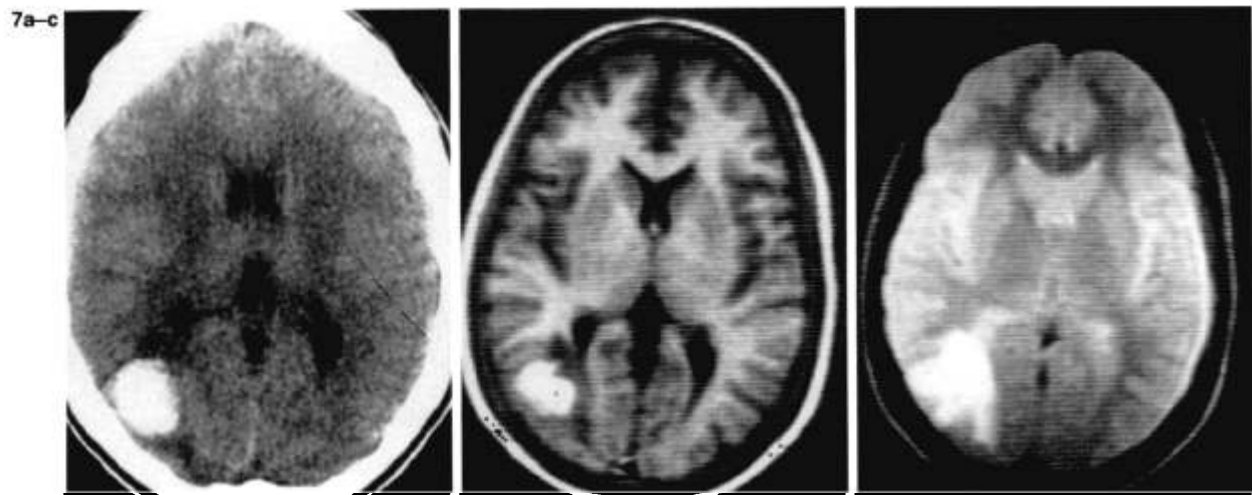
One week hematoma at 0.25 T. a: Twenty-four hours after sudden onset of seizures, noncontrast CT shows right posterior bleeding. b: T1-weighted image (IR: TR 1,700/TI 400 ms) 5 days later shows hyperintense right blood collection (T1 lowering by methemoglobin) easily separated from hypointense edema. c: T2-weighted image (TR 1,700/TE 80 ms) shows hyperintensity because hemolysis has eliminated the susceptibility effect and reduced the protein effect on T2.
